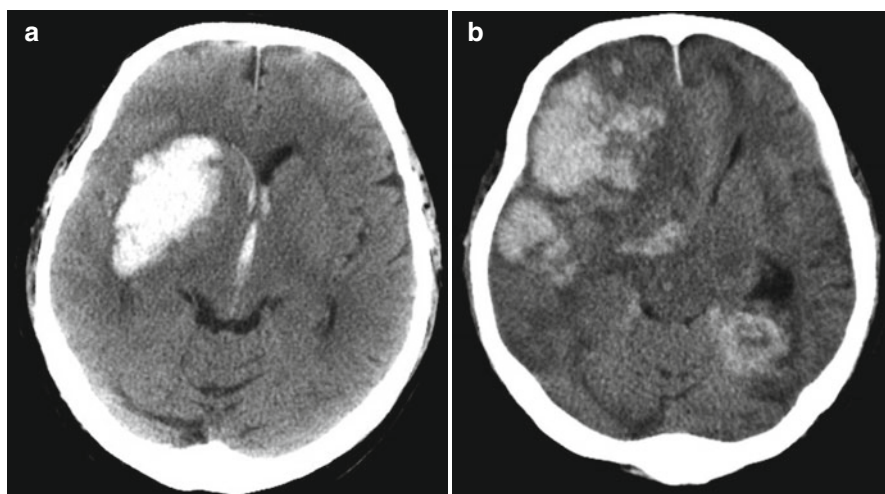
Unenhanced CT images of spontaneous intracerebral haemorrhage. (a) Due to hypertension; (b) due to a coagulation disorder; (c) tumor hemorrhage (nativ and with contrast
